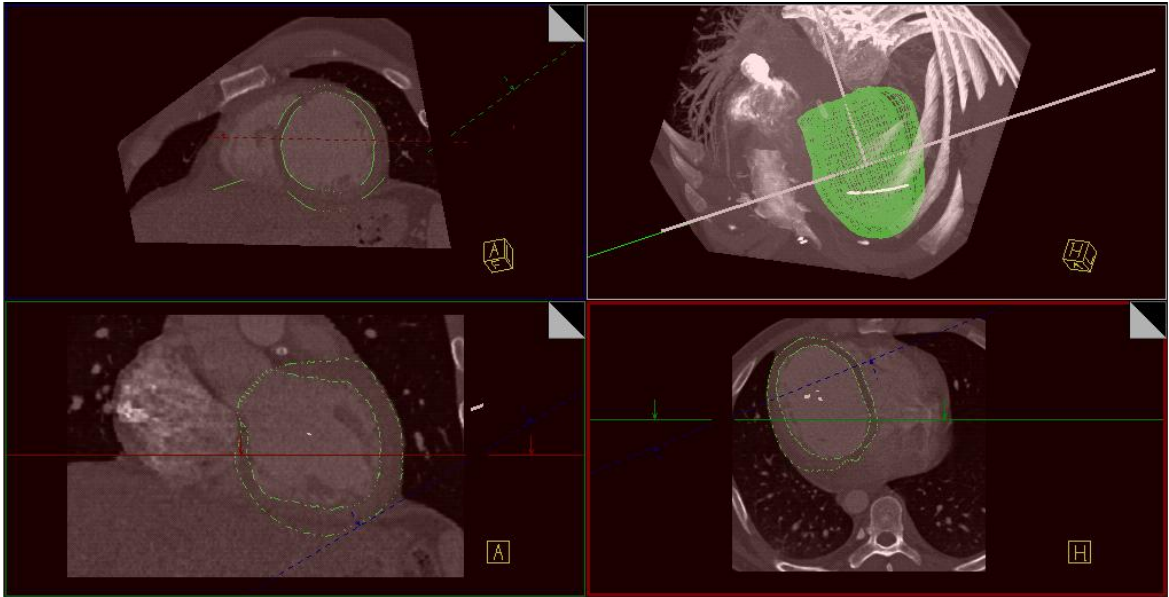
The CTA volume for Patient 1 with the geodesic model of the LV in green.
